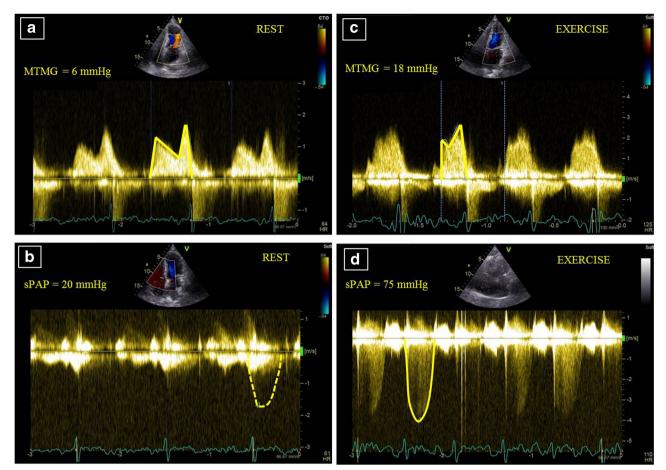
Exercise echocardiography in a 58-year-old women with moderate mitral stenosis and exercise dyspnea. a Resting mean transmitral gradient (*MTMG*) showing moderate mitral stenosis (mean gradient 6 mmHg and mitral area estimated at 1.6 cm²). b Resting systolic pulmonary arterial pressure (sPAP) assessed by transtricuspid gradient (probably underestimated due to very mild tricuspid regurgitation at rest) and right atrial pressure. c Exercise transmitral gradient showing a significant increase in mean gradient at peak exercise. Patient presented with dyspnea with limited exercise workload (75 W). d Exercise sPAP showing an abnormal increase in sPAP (>60 mmHg) and in slope of PAP-CO (>3 mmHg/L/min).
